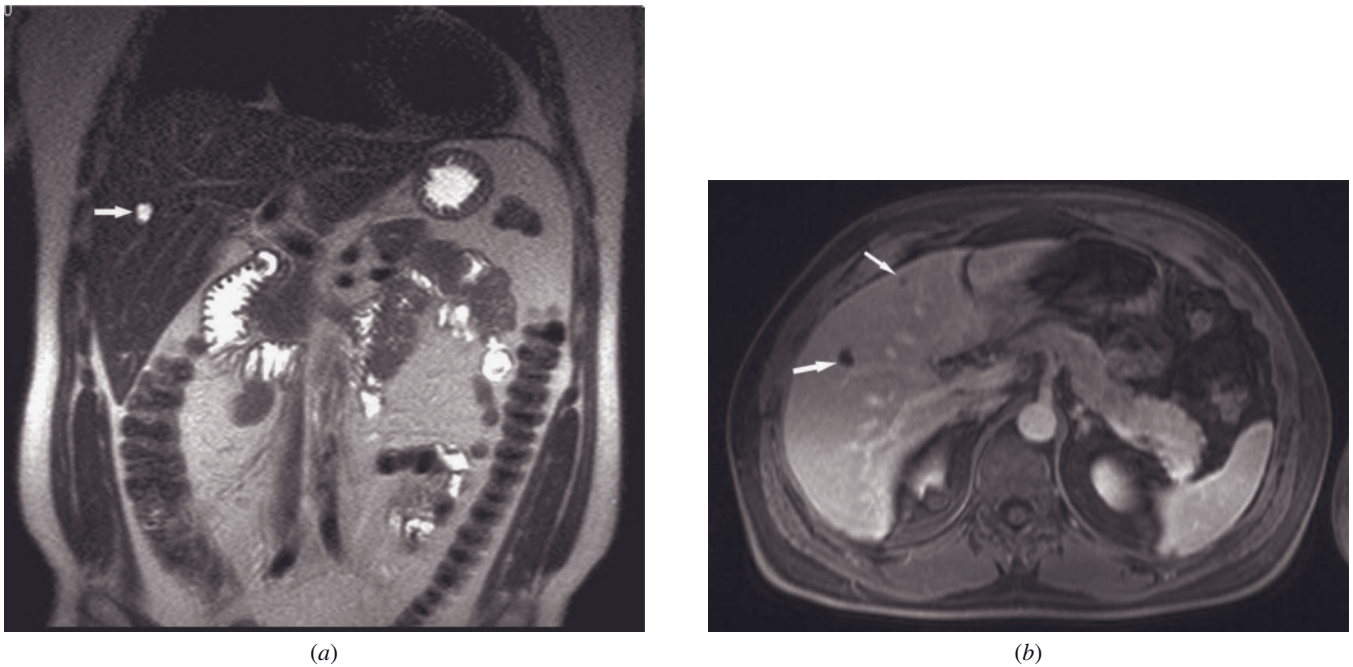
Liver. Coronal T2-weighted single-shot echo-train spin-echo image (a) shows a high-signal-intensity lesion consistent with biliary hamartoma (arrow). Axial T1-weighted fat-suppressed postgadolinium 3D gradient echo image (b) shows the biliary hamartomas with low signal intensity (arrows).
